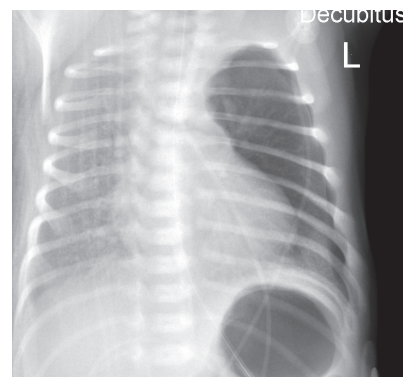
Chest X-ray – lateral decubitus position. Left pneumothorax is more evident.
